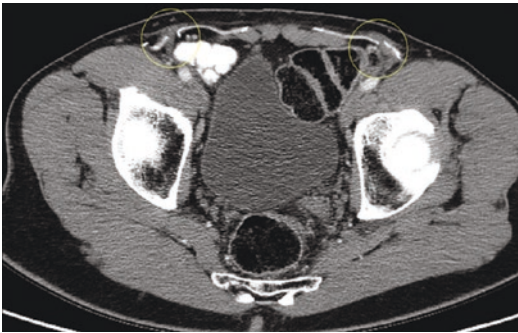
This patient was referred after an unrelated CT scan was interpreted as recurrent inguinal hernias through fractures in the mesh. On evaluation the patient was asymptomatic. On review of the images, it was determined the “recurrence” was actually the slit in the keyhole mesh to permit the cord structures (yellow circles)
